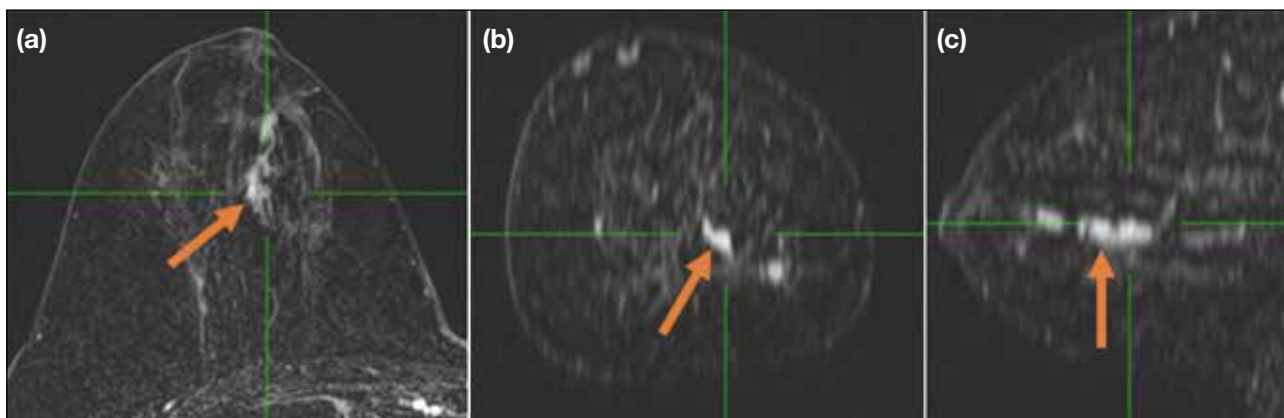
A 41-year-old woman with biopsy-proven right-sided ductal carcinoma in situ (DCIS) undergoing preoperative magnetic resonance imaging. (a) Reformatted axial post-contrast T1-weighted image with subtraction shows the DCIS as central ductal non-mass enhancement extending towards the nipple (arrow). Reformatted coronal (b) and sagittal (c) post-contrast T1-weighted images with subtraction (arrows).
